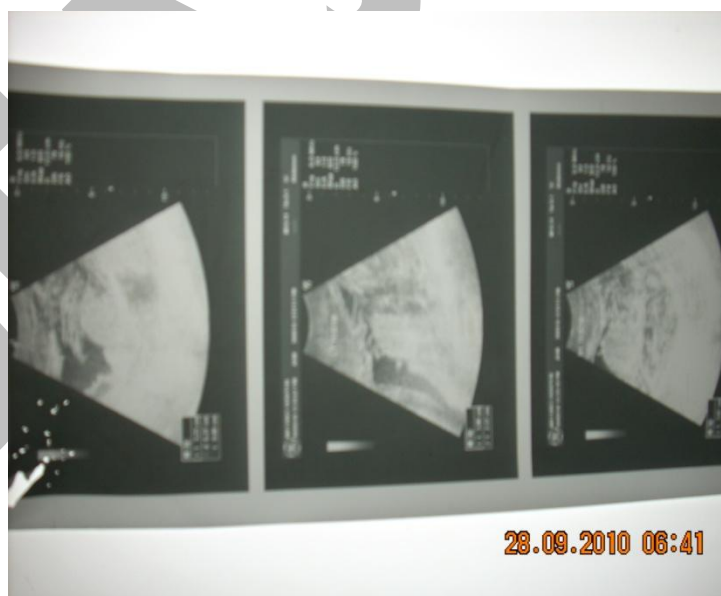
Ultrasound scrotum of affected part
